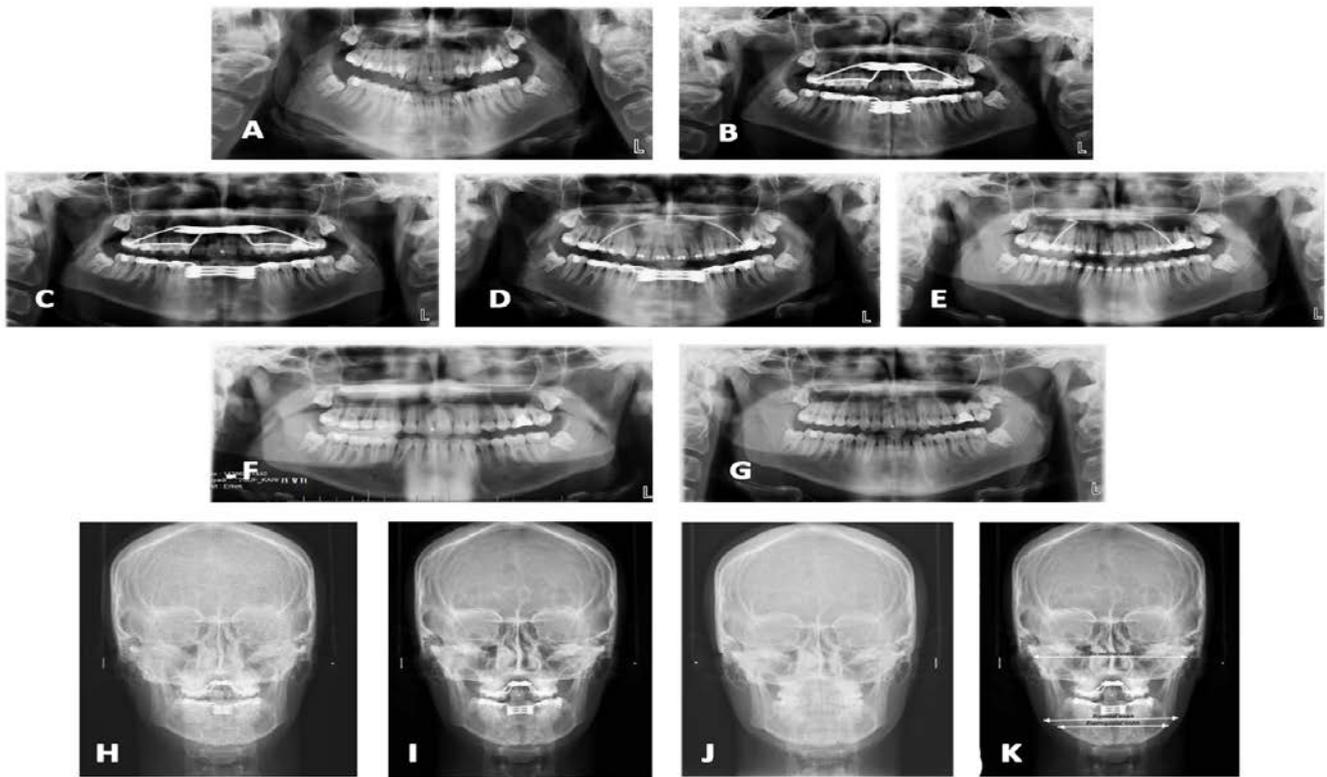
Panoramic radiographs of patient. A: Pre-treatment, B: Post-osteotomy, C: Distraction phase, D: Consolidation phase, E: Post-consolidation, F: Post-treatment, G: One-year follow-up, H: Posteroanterior radiograph of post-osteotomy, I: Posteroanterior radiograph of distraction phase, J: Posteroanterior radiograph of post-treatment, K: Posteroanterior measurements.
